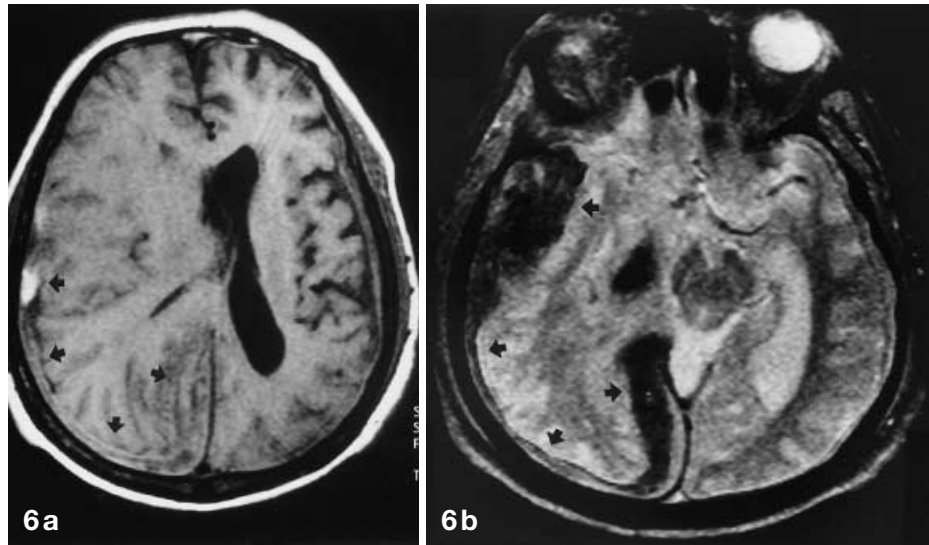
Infarct and hemorrhage in a 48-year-old ESRD patient who developed sudden visual loss after 1 year of dialysis therapy. a A FLAIR image shows acute infarct in the left posterior parietal region. b Gradient-echo axial image demonstrates right occipital-posterior parietal and left posterior parietal acute infarcts with hemorrhage in the left, and chronic hematoma in the right external capsule and putamen with hypointense rim (*arrows*)
